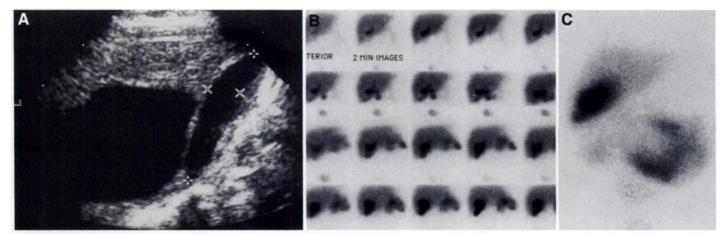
Congenital hepatic cystic mass. Antenatal ultrasound revealed a cystic mass close to the gallbladder. At 2 wk, an ultrasound (A) confirmed the cystic mass in the right lobe of the liver close to the gallbladder (markers). Biliary scan initially showed a photon-deficient area adjacent to the functioning gallbladder. Later images show filling of the cystic mass with tracer (B), indicating communication of the cyst with the biliary system. Delayed images at 3 hr (C) confirm retention of tracer in the mass with most of the tracer having cleared from the liver and biliary tree.
